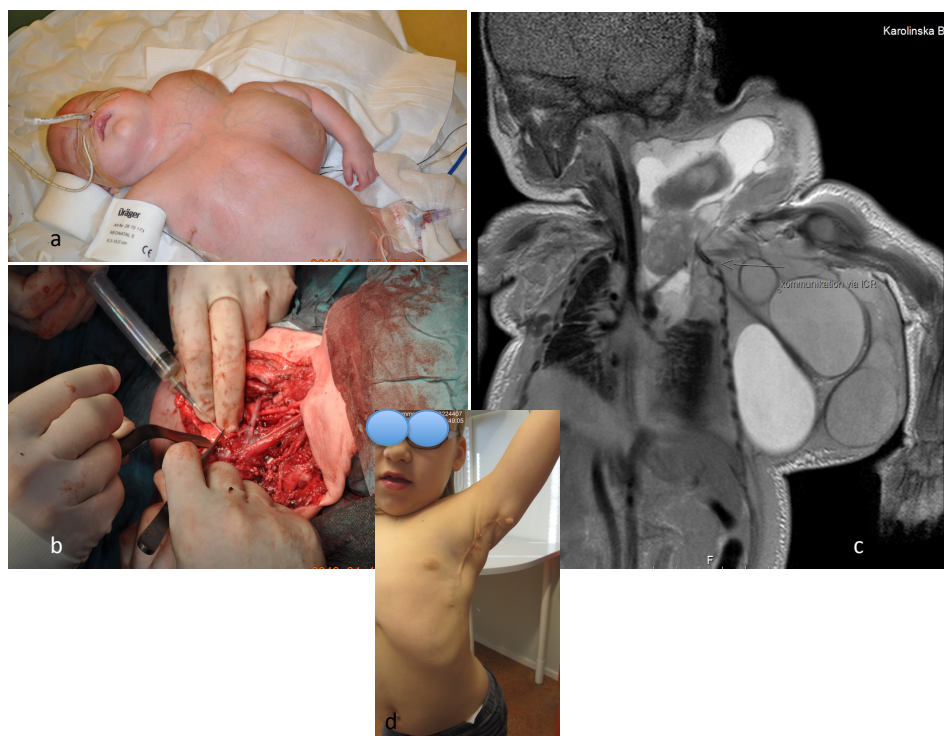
Mixed LM with mediastinal expansion a clinical features at EXIT assisted delivery, b surgical debulking around the vital structures in the mediastinum and intraoperative sclerotherapy, c MRI T2 weighted image showing mixed LM with cysts expanding into the mediastinum compressing the heart and the left main bronchus d clinical outcome after stages surgeries and adjuvant sclerotherapies.
